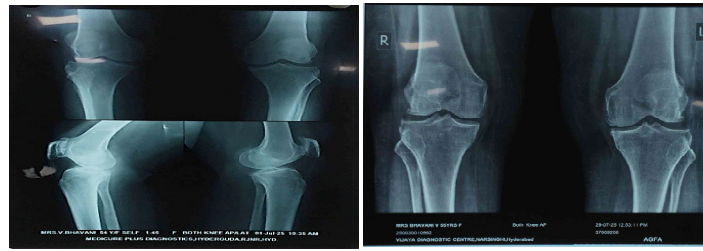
Pre and Post therapy knee x-rays
